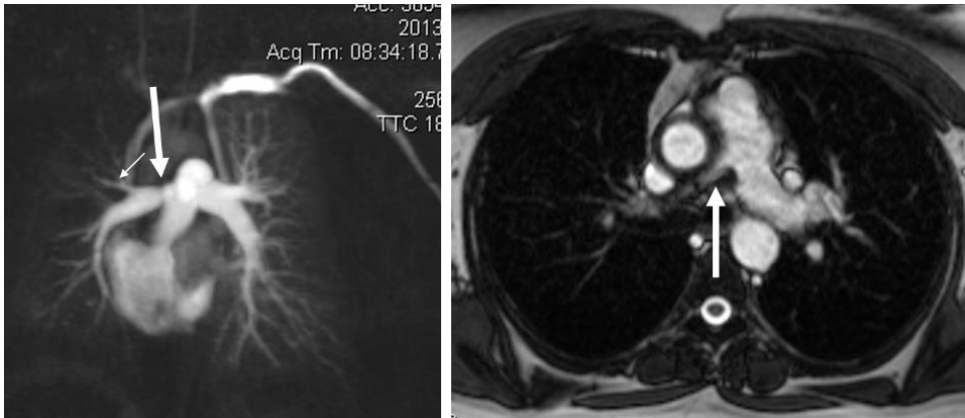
Main right pulmonary artery stenosis in a patient with Takayasu arteritis (CT-angiography, frontal reconstruction and axial image).
